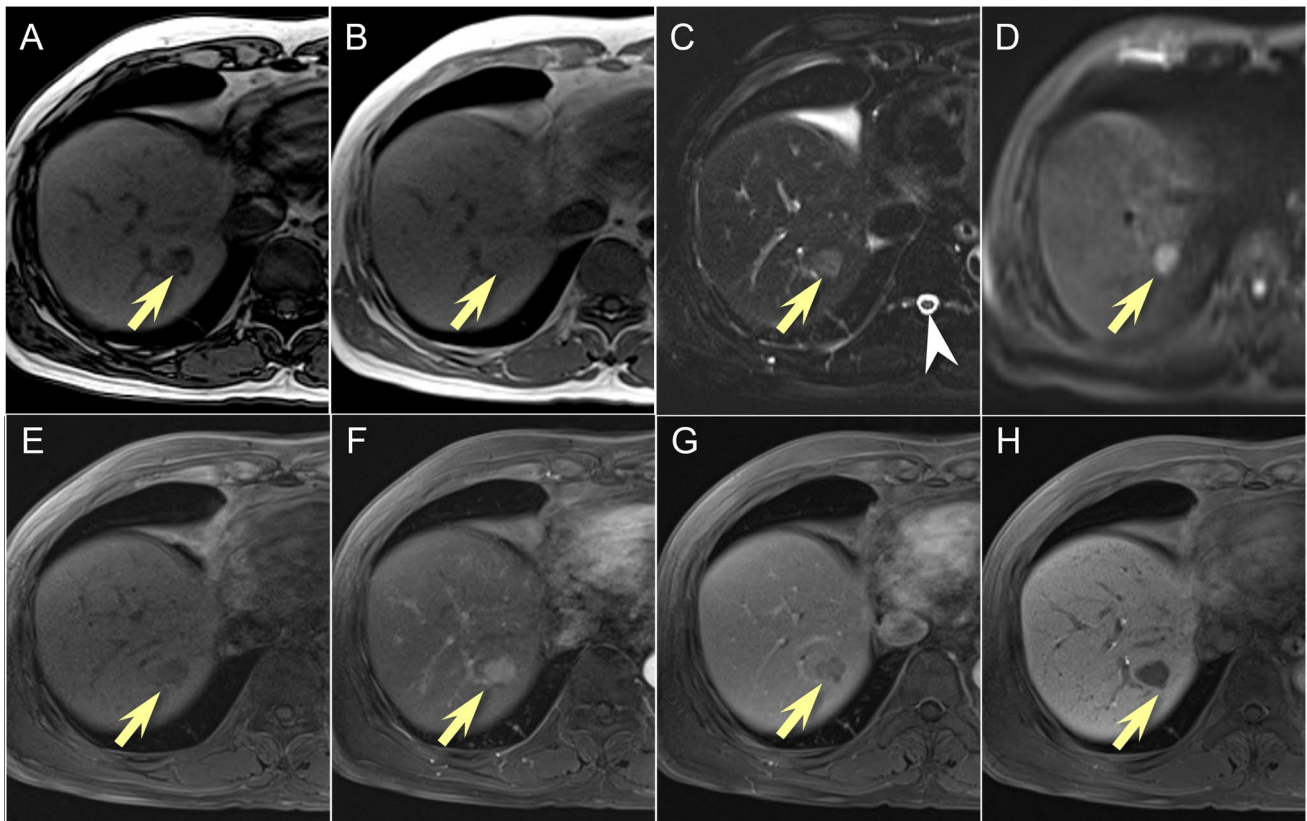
Typical appearance of hepatocellular carcinoma (HCC) in complete gadoteric acid-enhanced liver MRI. In a 55-year-old man with hepatitis B-associated liver cirrhosis, a 1.6-cm HCC is seen in segment VII of the liver (arrows). In the T1-weighted opposed-phase image (A), the HCC exhibits a signal drop compared to that in the T1-weighted in-phase image (B), suggesting the presence of intralobular fat. C In the fat-saturated T2-weighted image (C), the HCC appears only mildly hyperintense, whereas the cerebrospinal fluid in the spinal canal exhibits a much brighter signal intensity (arrowhead).
